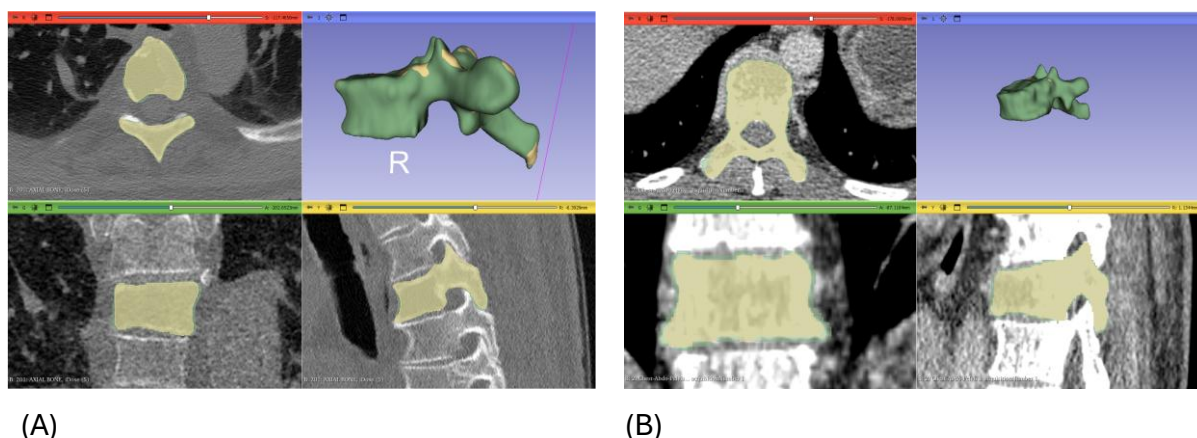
Representative segmentations of (A) Lytic 1 – CT scan with the best scan quality (B) and Lytic 4 – CT scan with the worst scan quality.
